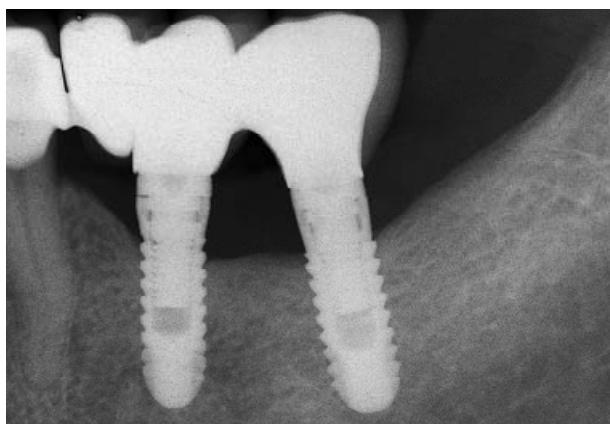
At 4 years after surgery with EMD the radiographs indicates a defect fill (case 2 from Table 1).
